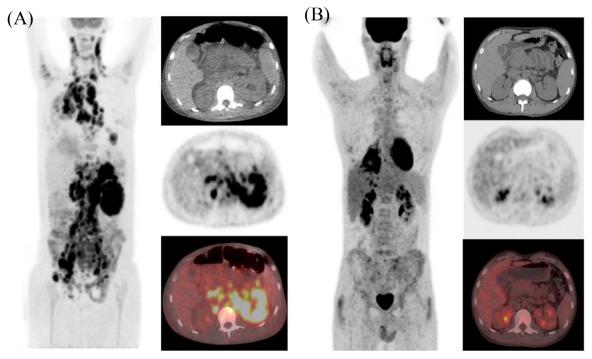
(A) Staging (at diagnosis) ¹⁸FDG-PET/CT demonstrated extensive cervical, thoracic and abdominal lymph nodes, spleen and bone involvement characterized by a high ¹⁸FDG uptake. The left renal mass also presented a high diffusely increased ¹⁸FDG uptake suggesting renal lymphoma involvement. (B) Post-treatment ¹⁸FDG-PET/CT demonstrating remission of previous lesions and a symmetrical ¹⁸FDG uptake by the kidneys. Late images showed reduction of both renal uptakes, suggesting physiological urinary clearance of the radiotracer.
